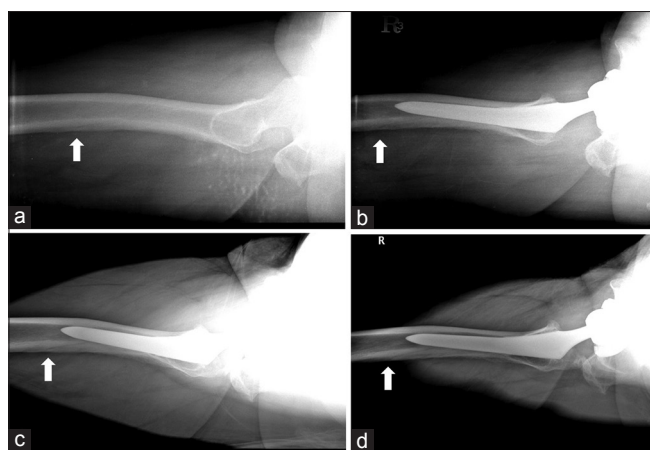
Cross-table lateral hip radiographs of a 62-year-old male show a nutrient artery canal (white arrow), of which upper end was proximal to the implant tip. Shape and length of the nutrient artery canal is unchanged throughout the postoperative followup (a-d). (a) Preoperative period. (b) Postoperative 2 weeks. (c) Postoperative 6 months. (d) Postoperative 3 years
